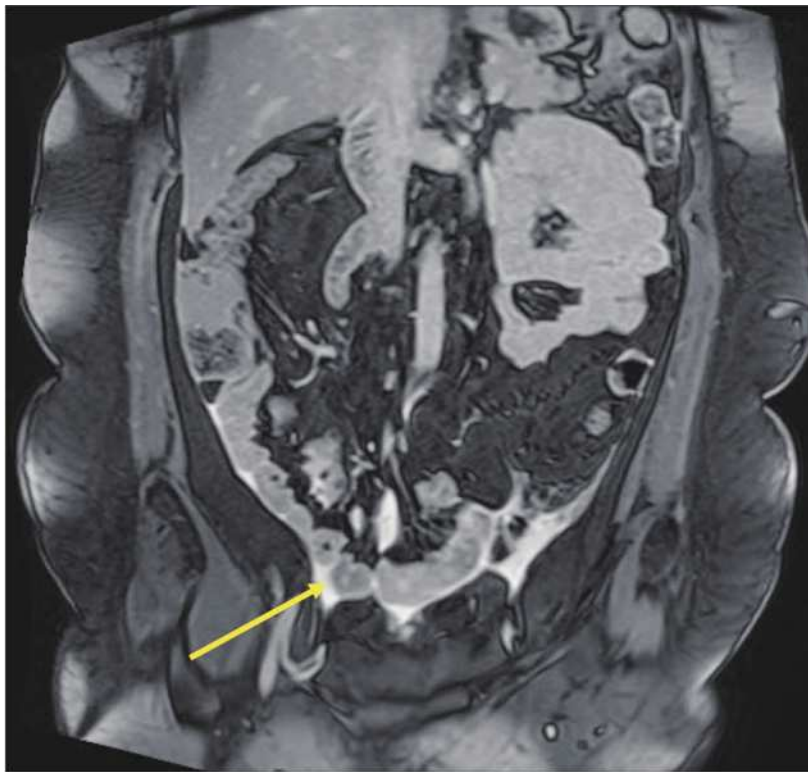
Coronal MRI of the abdomen and pelvis shows small pelvic ascites with suspected contrast extravasation, consistent with urinary leakage. No hydronephrosis or renal lesions are observed. (Abbreviation: MRI: magnetic resonance imaging)
